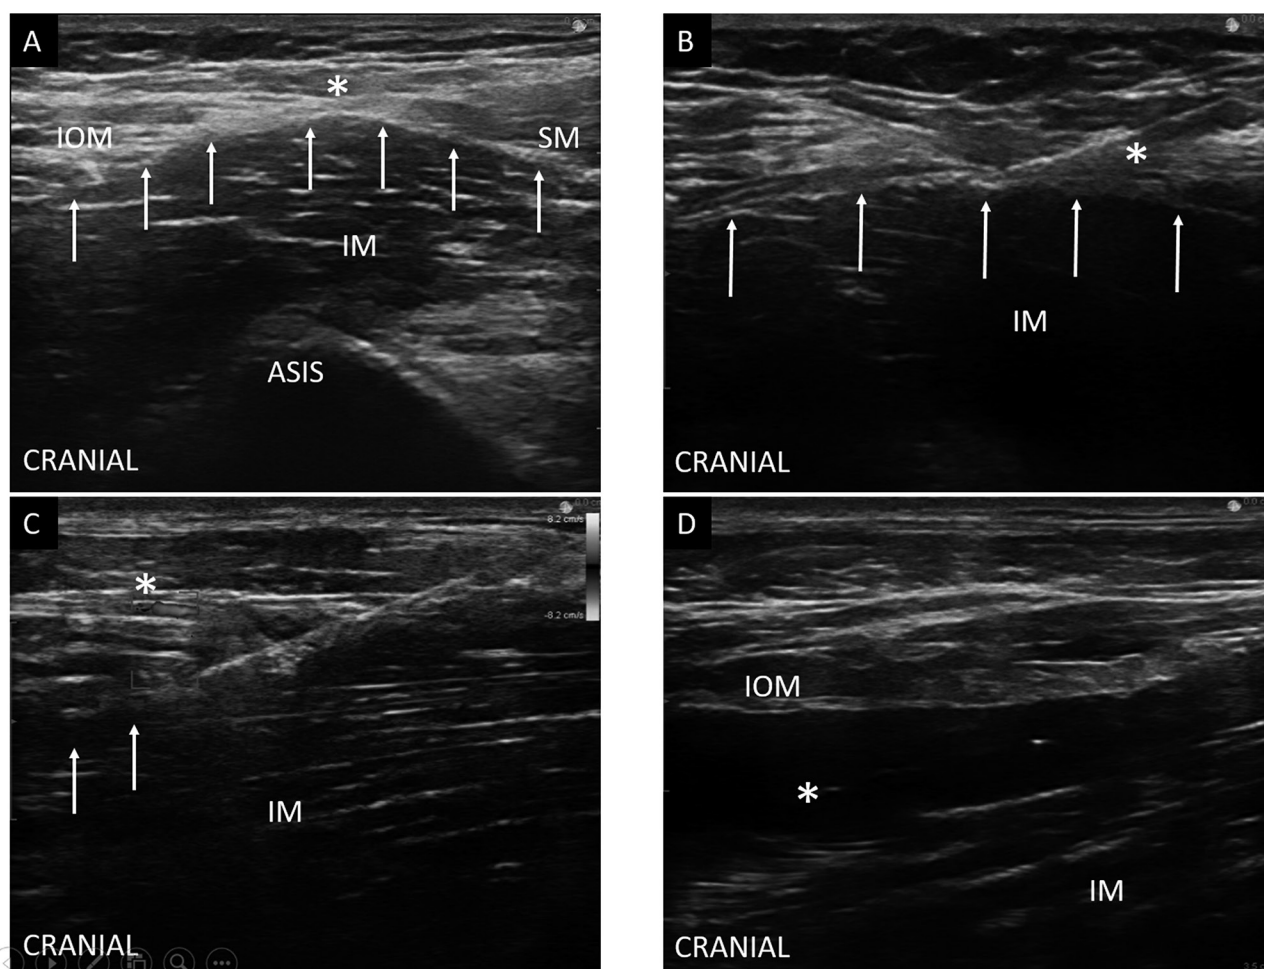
Ultrasound image of a longitudinal supra-inguinal FICB
